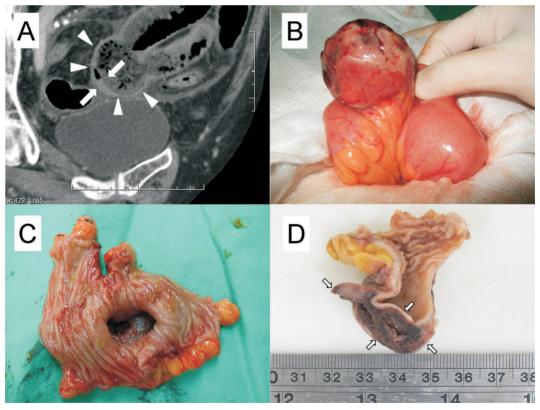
CT image demonstrates a mechanical ileus with an outpouch (arrowhead) at the distal ileum. The outpouch is expanded by an intraluminal bezoar. The tip of the outpouch (arrow) is mildly thickened (A). External view of the perforated Meckel's diverticulum at the antimesenteric border of the terminal ileum (B). Internal view of the Meckel's diverticulum (C). A brownish fusiform lesion (arrow) is seen at the tip of the diverticulum after bisection. The lesion mimics a hematoma or purulent exudate covering the perforated Meckel's diverticulum (D).
